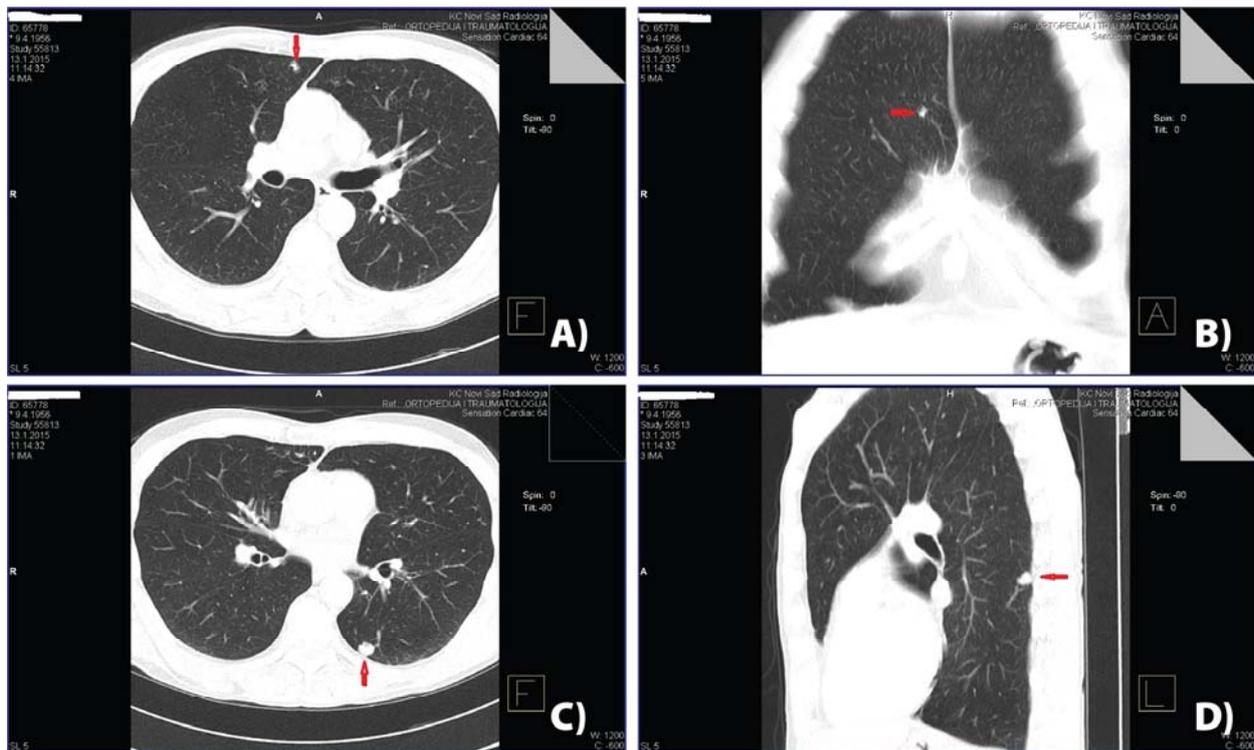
Computed tomography (CT) appearance of tumors in the lungs. No invasion of the bronchi, main blood vessels nor bone structures. No effusion in the pleural space.
